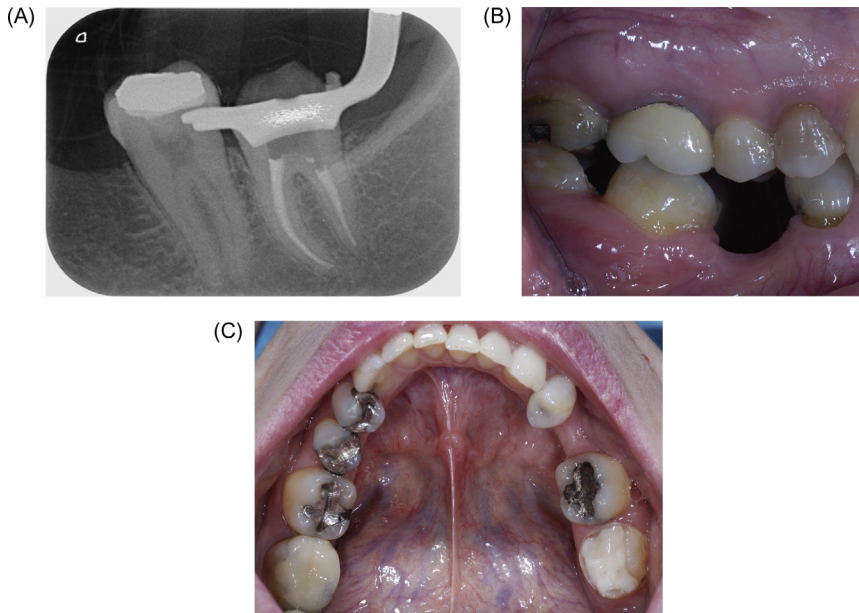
Preoperative situation: (A) radiograph; (B) lateral view; (C) occlusal view.
